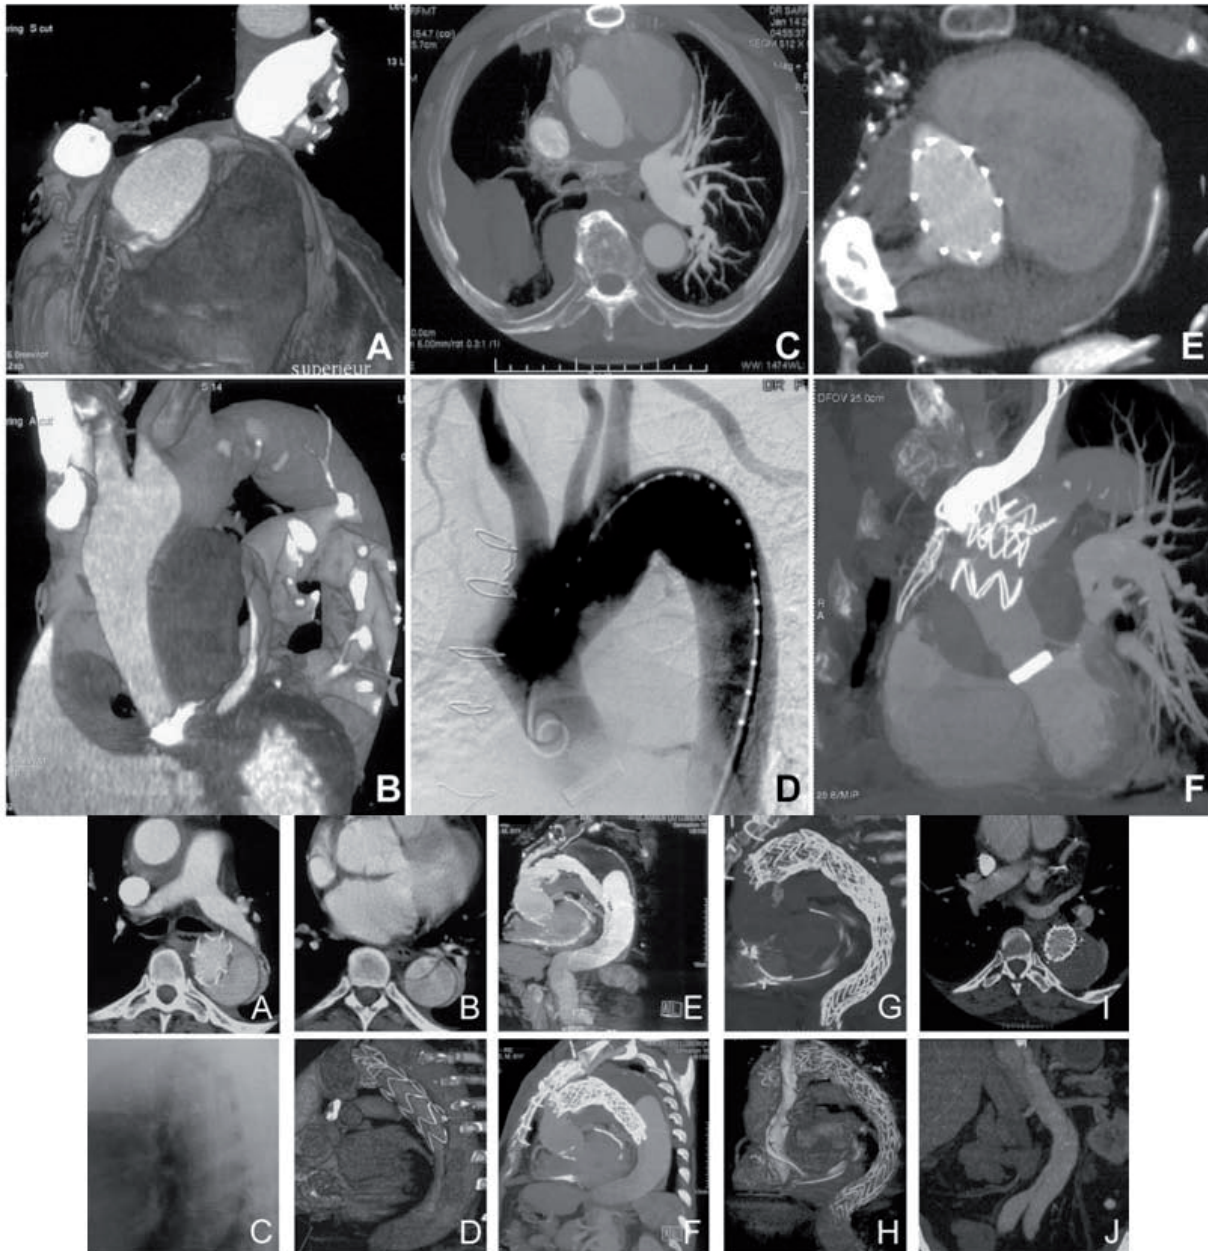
This 83-year old male patient had a previous Bentall operation in 2000. When he was admitted in November 2004, this patient was suffering from an effort dyspnea that had begun 3 months earlier. The angio CT scan showed a large 93-mm bulge surrounding the ascending aorta immediately distal to the replaced aortic valve (A-D). A limited right pleural effusion was also observed (C). A hybrid strategy was decided consisting in a preliminary transposition of the IA to the left CCA. The intra-operatively TEE showed that the aneurysm was poorly circulating and its posterior half was almost thrombosed; its blood flow was estimated to originate from the distal anastomosis of the aortic graft. Two months later the patient came back to our department to receive the aortic endograft. A
